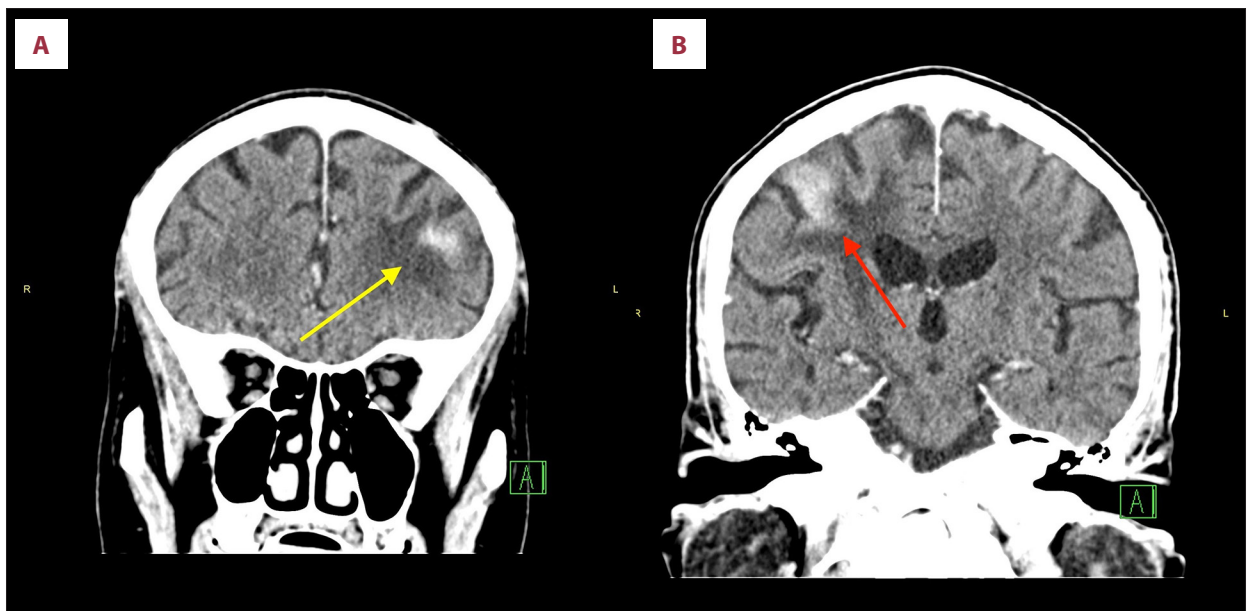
Coronal views of CT head showing hyperdense lesions in the left frontal lobe (A) (yellow arrow) and right frontal lobe (B) (red arrow) with surrounding areas of hypodensity.
